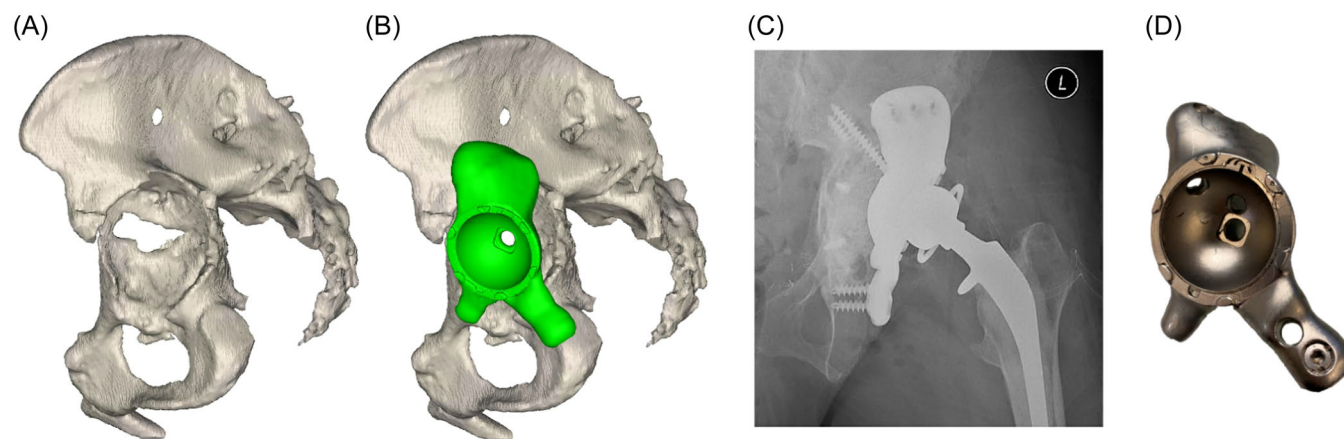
A revision THA with FAC patient case, performed at our institution. (A) 3D reconstruction of the defect hip geometry, (B) bone and implant, (C) postoperative radiograph (cropped to show the FAC), (D) retrieved implant.
